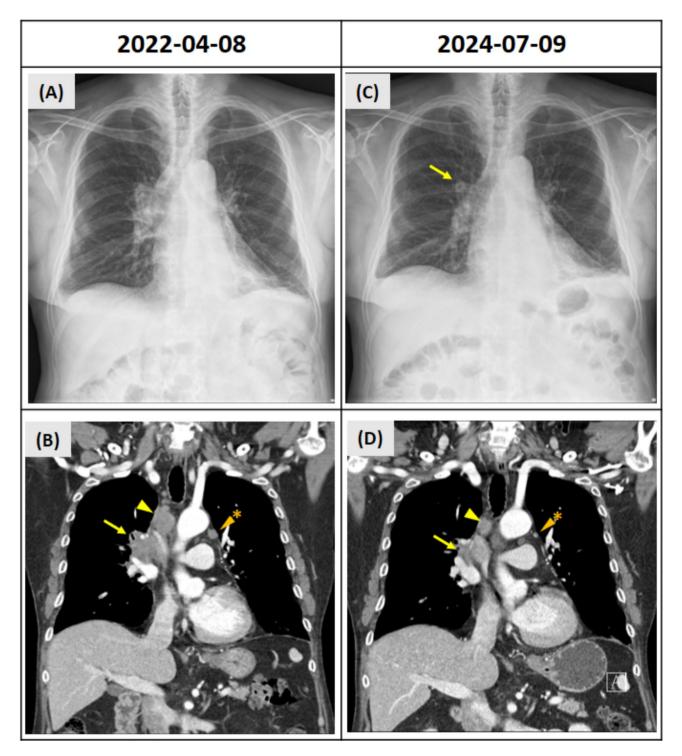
Serial images of the patient's chest X-ray (CXR) and chest computed tomography (CT). (A, B) The 2022 CXR and chest CT continue to show same findings compared to 2021, with the enlarged 4R (yellow arrowhead) and 5R (orange arrowhead with star) lymph nodes, along with a mass-like lesion anterior to the right upper lung (yellow arrow). (C, D) The 2024 CXR and chest CT demonstrate significant improvement in the peribronchial soft tissue and lymph node size
